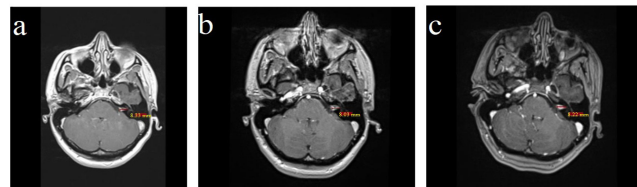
MRI scan: a) initial, b) 2 years after diagnosis, c) 3 years after diagnosis
